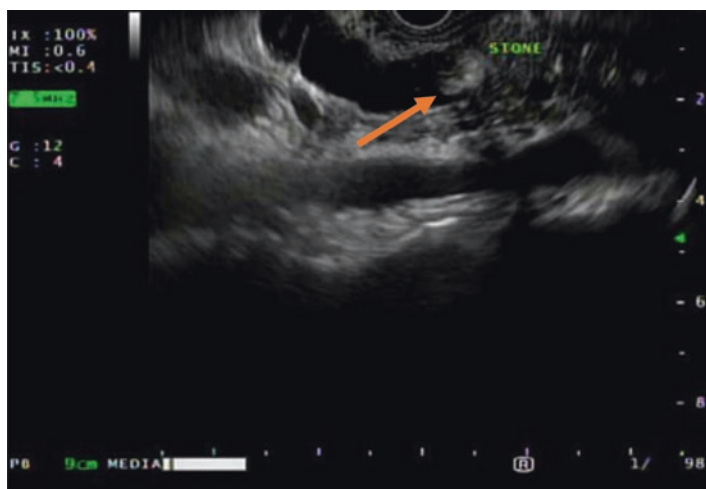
Endoscopic ultrasonography reveals a shadowing stone (arrow) in the distal common bile duct
